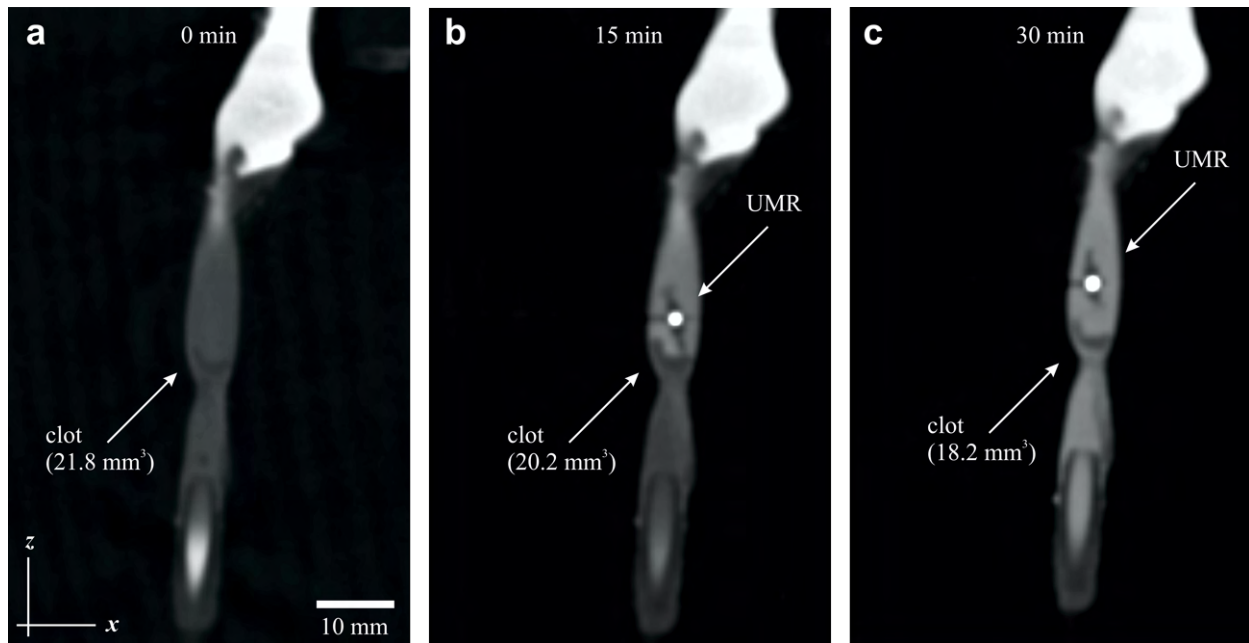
Pre- and post-interventional CBCT scans are collected every 15 minutes to establish the control and the fragmentation measurement, respectively. The size of the blood clot is measured from reconstructed scans, with the bright region indicating the UMR. (a) Initial blood clot volume measured using volume acquisition CT is 21.8 mm^3 . (b) After 15 minutes, the volume decreases to 20.2 mm^3 . (c) Grinding the blood clot for 30 minutes results in a volume reduction of 16%, yielding a clot volume of 18.2 mm^3 . Please refer to supplementary multimedia.
